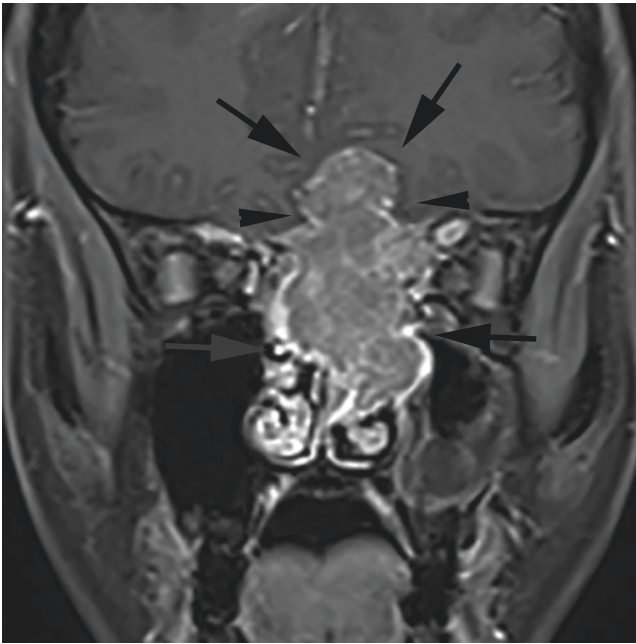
Olfactory neuroblastoma. Coronal Gd-enhanced T1-weighted image. An enhanced tumorous lesion (arrows) is found to extend intracranially from the nasal cavity sandwiching the cribriform plate of ethmoid bone with dumbbell-shaped configuration (arrowheads)
